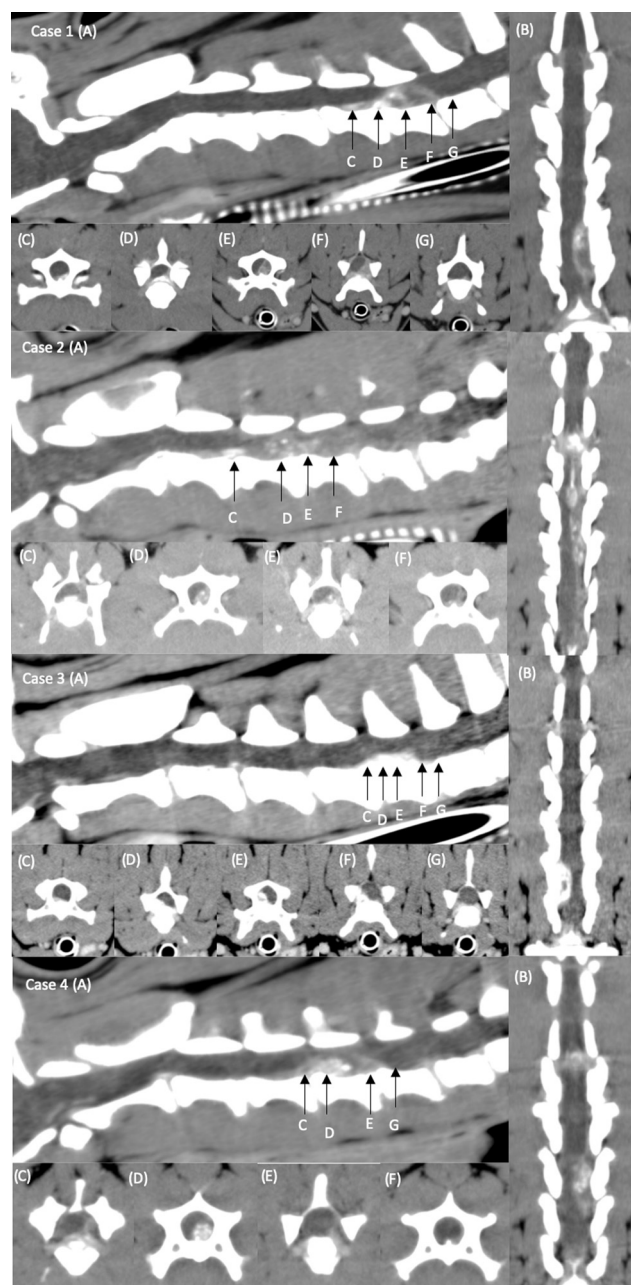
Post-contrast (soft tissue window) computed tomography images of cases 1 to 4. In soft tissue window, before surgery: (A) Sagittal view (cranial to the left, dorsal on top of the image), (B) dorsal view (cranial on the top of the image, the left is on the right side of the image), (C–F) Transverse images (the left is on the right side of the image). An extensive heterogeneously hyperattenuating material (compared to the spinal cord) suggestive of extruded degenerated disc mixed with epidural haemorrhage is observed in the four cases, compressing the spinal cord. The black arrows on the sagittal images correspond to the area of the sections of transverse images.
